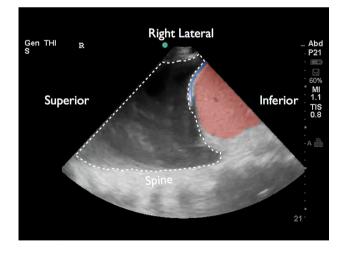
Pleural effusion. The liver is identified by the area of *red shading*. Superior to the liver, the lateral portion of the right diaphragm is identified by the overlying *blue line*. Superior to the diaphragm, an anechoic or *black area* is outlined by the *white dashed line* and represents fluid in the pleural space. Due to the presence of fluid in the pleural space, which is an excellent conductor of ultrasound waves, the spine can be visualized *midline*. The spine would not be visualized through normal aerated lung as air scatters ultrasound waves. [See Supplemental Video 1] (Color figure online)
